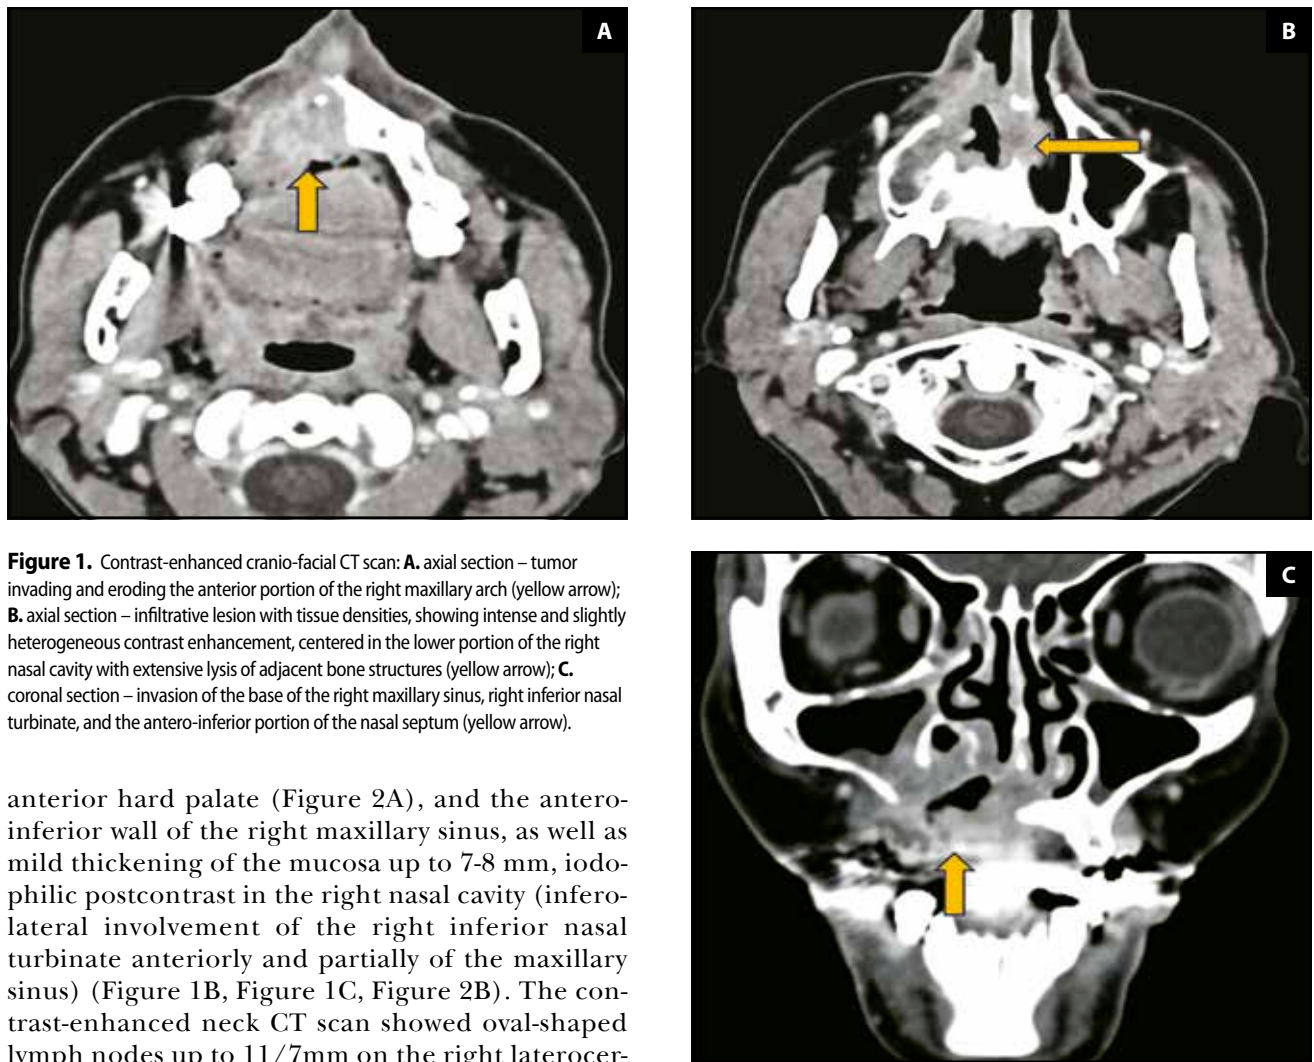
Contrast-enhanced cranio-facial CT scan: A. axial section – tumor invading and eroding the anterior portion of the right maxillary arch (yellow arrow); B. axial section – infiltrative lesion with tissue densities, showing intense and slightly heterogeneous contrast enhancement, centered in the lower portion of the right nasal cavity with extensive lysis of adjacent bone structures (yellow arrow); C. coronal section – invasion of the base of the right maxillary sinus, right inferior nasal turbinate, and the antero-inferior portion of the nasal septum (yellow arrow).
